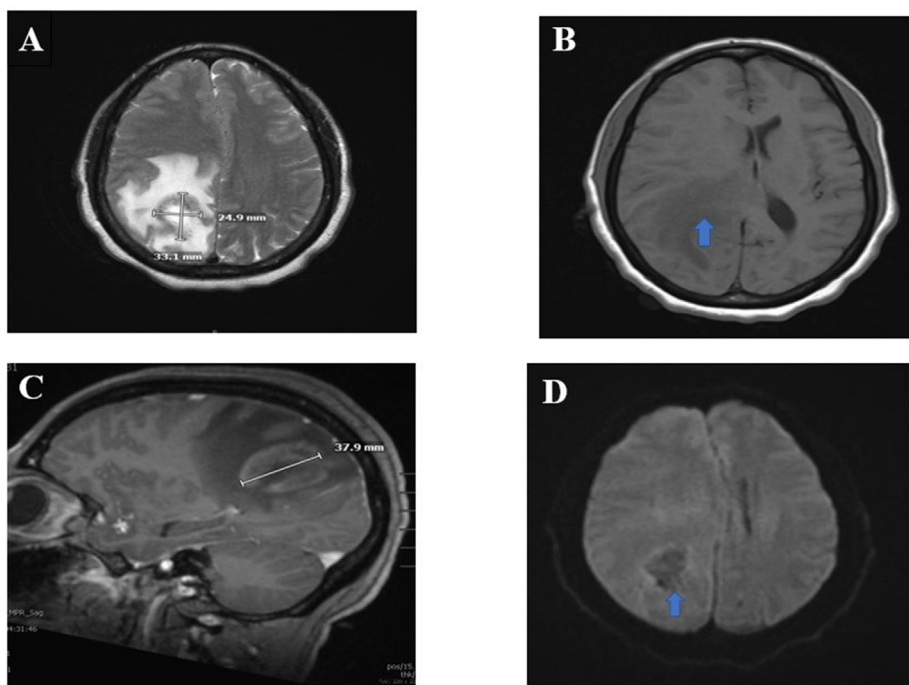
Magnetic resonance imaging (MRI) brain showing right parietal lobe, intra-axial mass with vasogenic edema and midline shift. (A) T2 weighted: demonstrates hyperintense lesion within the right parietal lobe with vasogenic edema and midline shift. Partial involvement of the posterior aspect of the corpus callosum(B) T1 weighted, pre-contrast: demonstrates hypointense lesion (C) T1 weighted post-contrast: demonstrates enhancing lesion (D) Diffusion weighted imaging (DWI): demonstrates minimal diffusion restriction.
